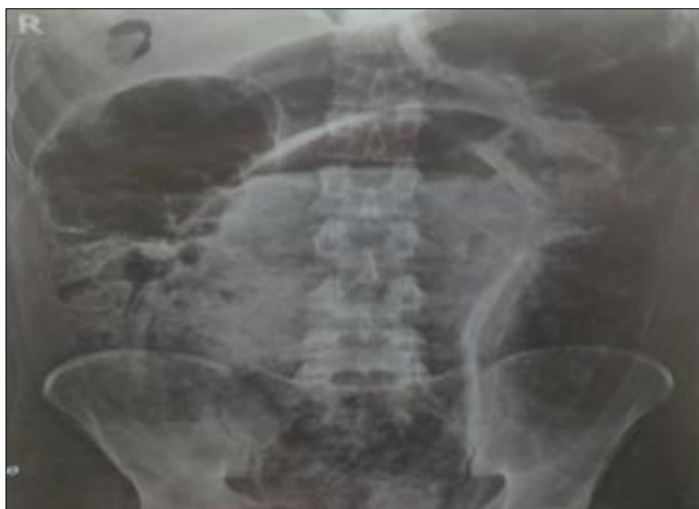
Abdominal X-ray (without preparation) showing aerocolia
